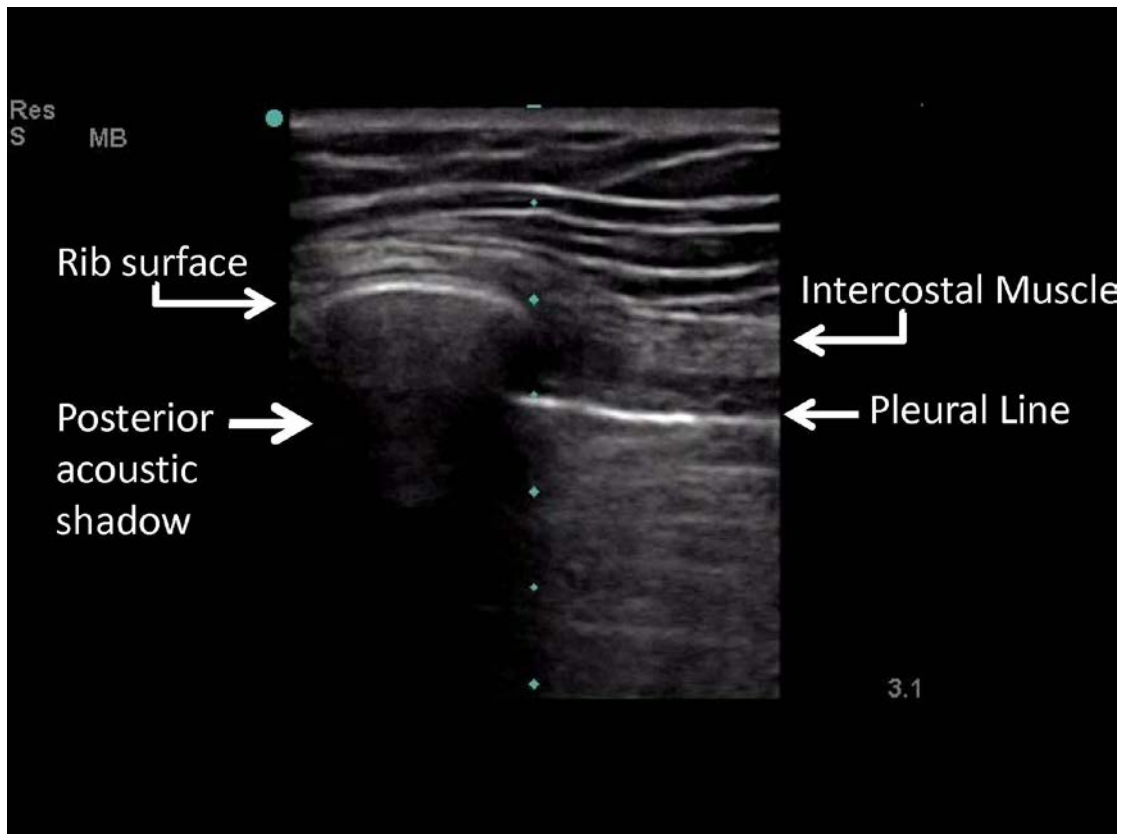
Ultrasound image of Intercostal space showing pleural line, intercostal muscle and rib surface.
